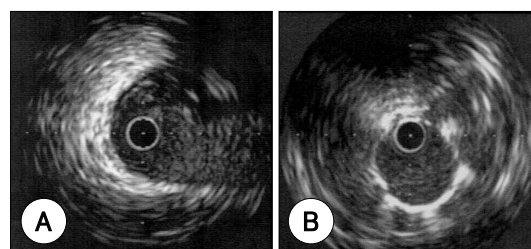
A: the IVUS image at the originating site of CAF before the implantation of the covered stent, B: the final IVUS image at the same site as in Fig A. The ostium of the feeding branch was jailed by the covered stent and obvious acoustic shadowing beneath the stent can be seen. CAF: coronary artery, IVUS: intravascular ultrasonography.
